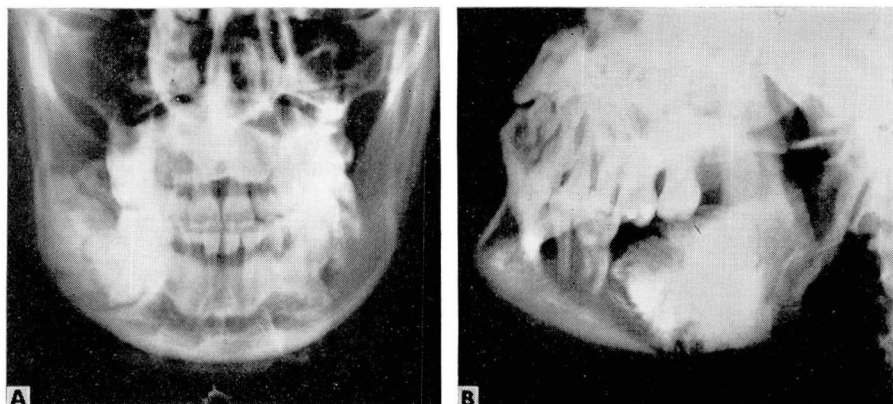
A and B, preoperative roentgenograms of the jaws, showing irregular radiopacity surrounded by radiolucent bands.
